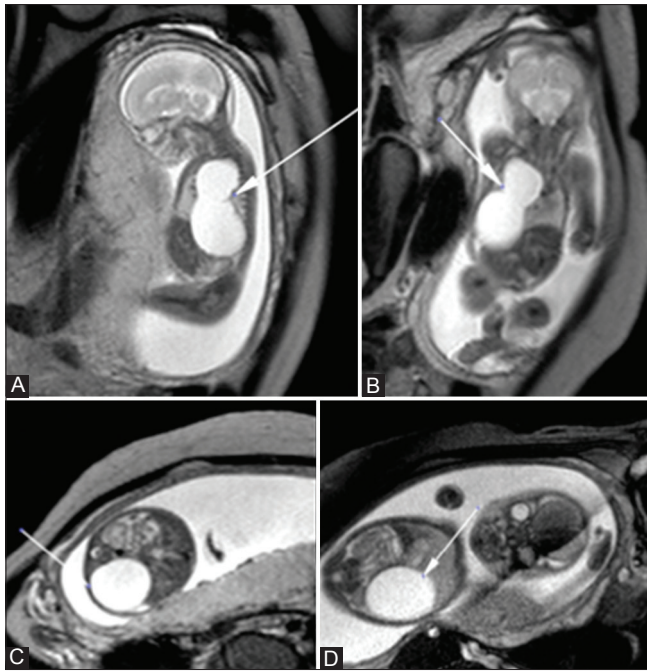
(A-D): Intrathoracic cyst/Bronchogenic cyst/CPAM type I or IV in a fetus at 22 weeks. T2WI sagittal, (A) coronal, (B and C) and axial (D) images showing 5.7 × 3 cm cystic mass occupying right hemithorax, causing diaphragmatic inversion and lung compression with thoracic scoliosis. In addition to it, MRI revealed ascites and bilateral pleural effusion
